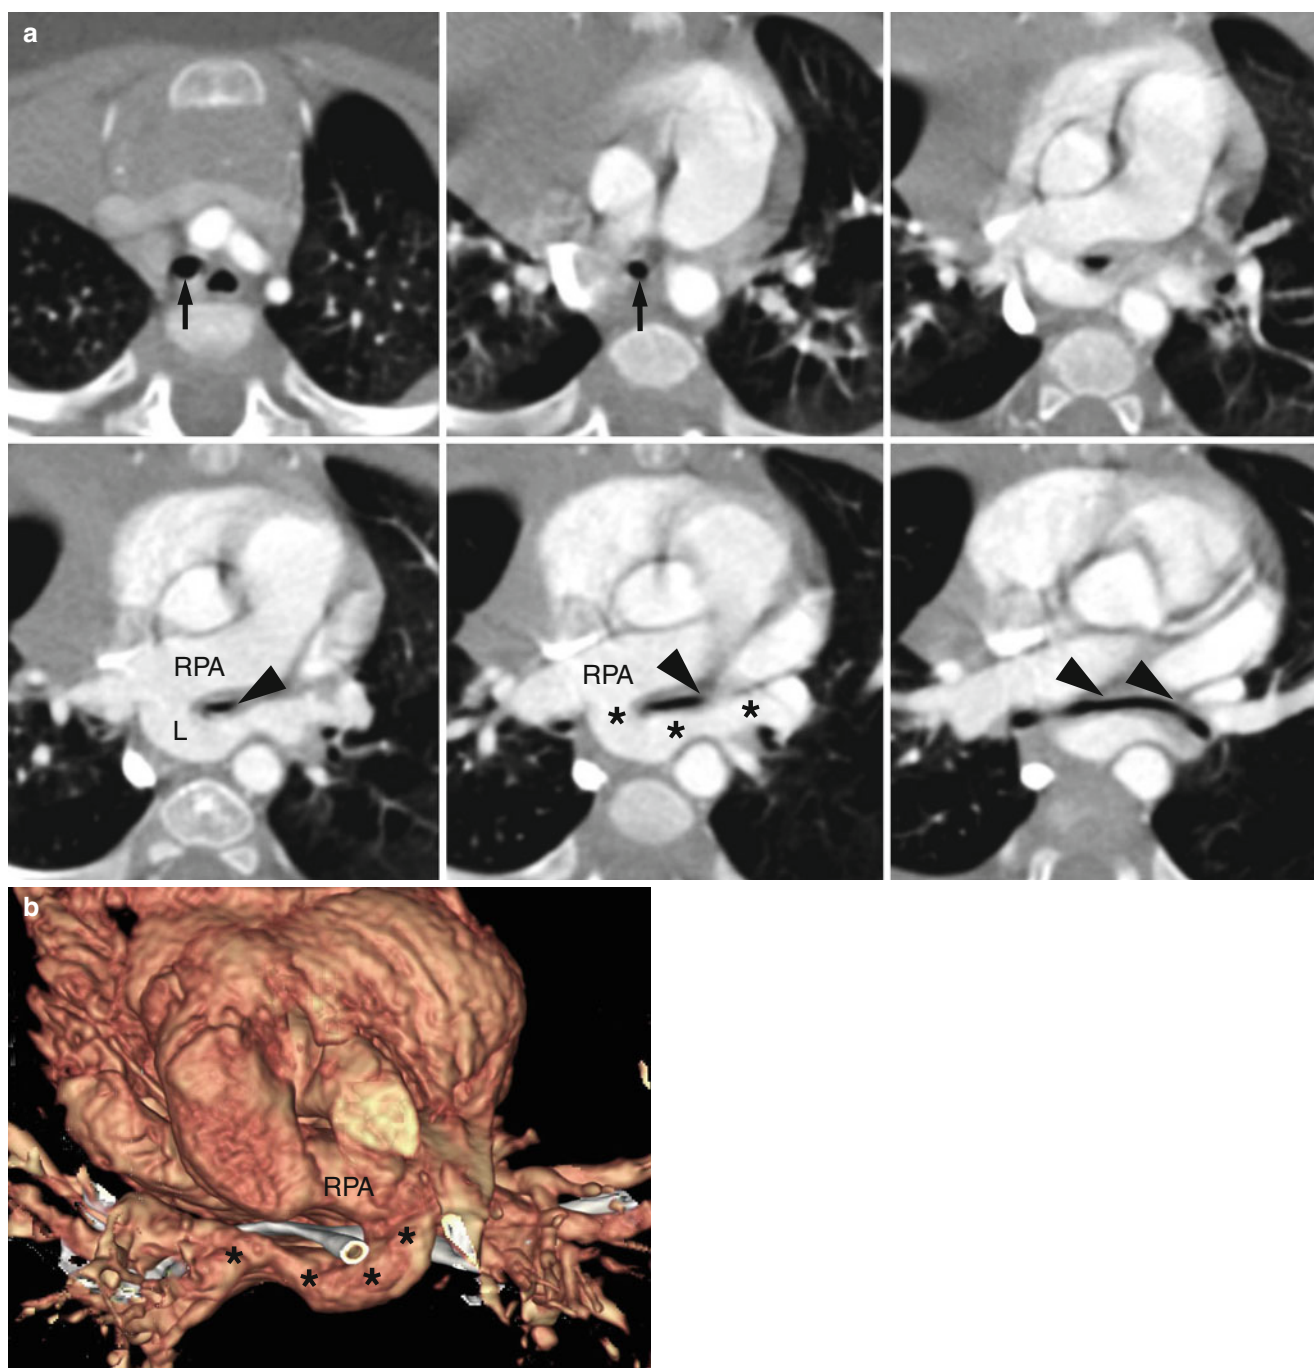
Pulmonary artery sling in a 6-month-old boy. (a) Axial CT images show aberrant origin of the left pulmonary artery (*L*) from the distal portion of the right pulmonary artery (*RPA*). A sling-like course of an anomalous left pulmonary artery sandwiches the distal trachea, carina, and left bronchus (*arrowheads*) to make the airways flat. Also, a diffuse concentric stenosis of the trachea (*arrows*) far superiorly apart
